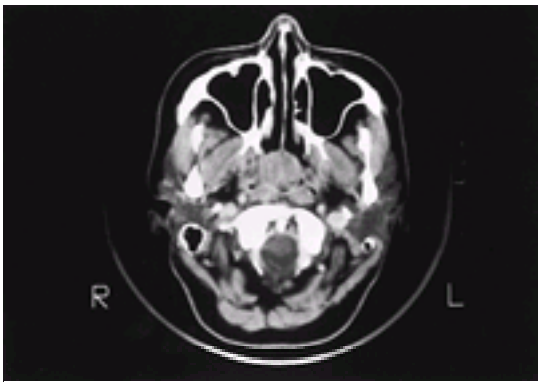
CT scan appearance of a large, polypoid nasopharyngeal carcinoma extending to the choana in a 42-year-old woman.
